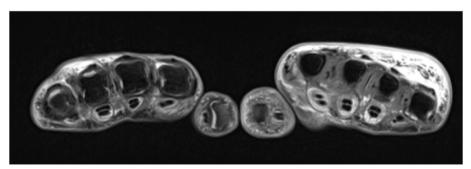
MRI hand pd + t2 tse fs transversal with contrast medium. In contrast-enhanced MRI of the hands, the transverse section shows a right accentuated enhancement of the contrast medium of the dorsal hand. Furthermore, a tenosynovitis of the flexor tendons of both hands is visible
